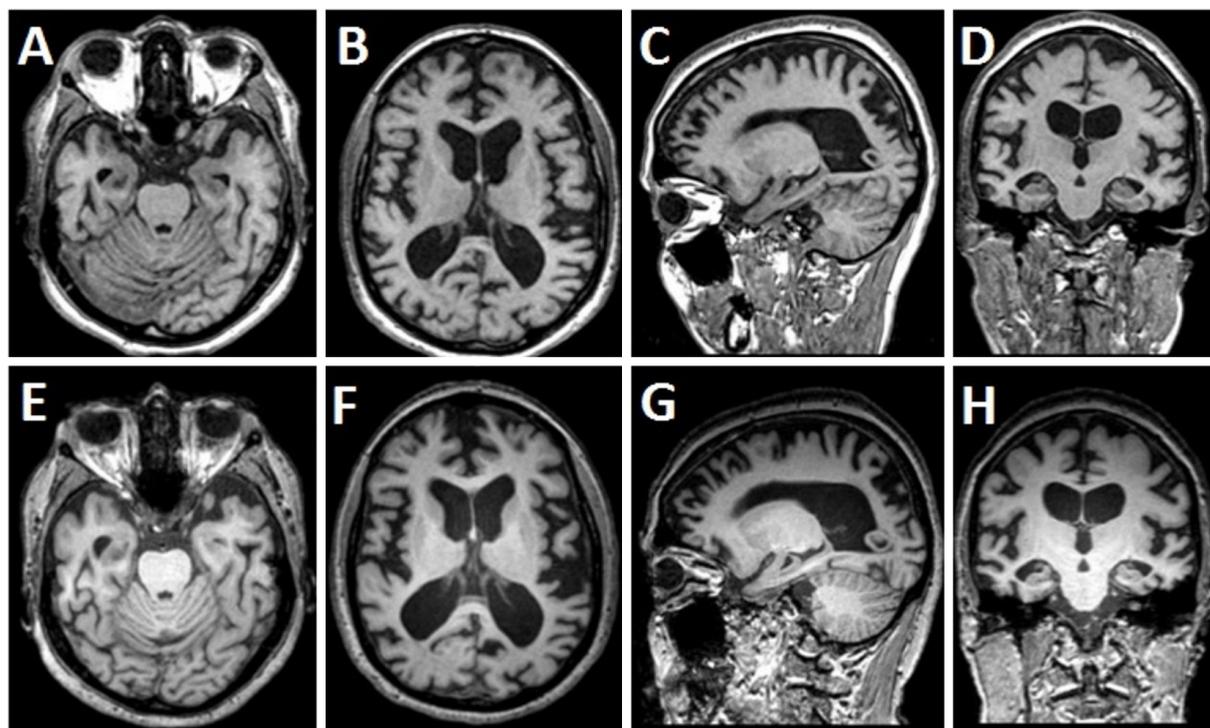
Brain magnetic resonance imaging of case 2 (T1 sequence) at age 57 (A-D) and 58 (E-H), showing progressive hippocampal atrophy (A, D and E, H), and frontal, perisylvian and parietal atrophy (B, C and F,G)
